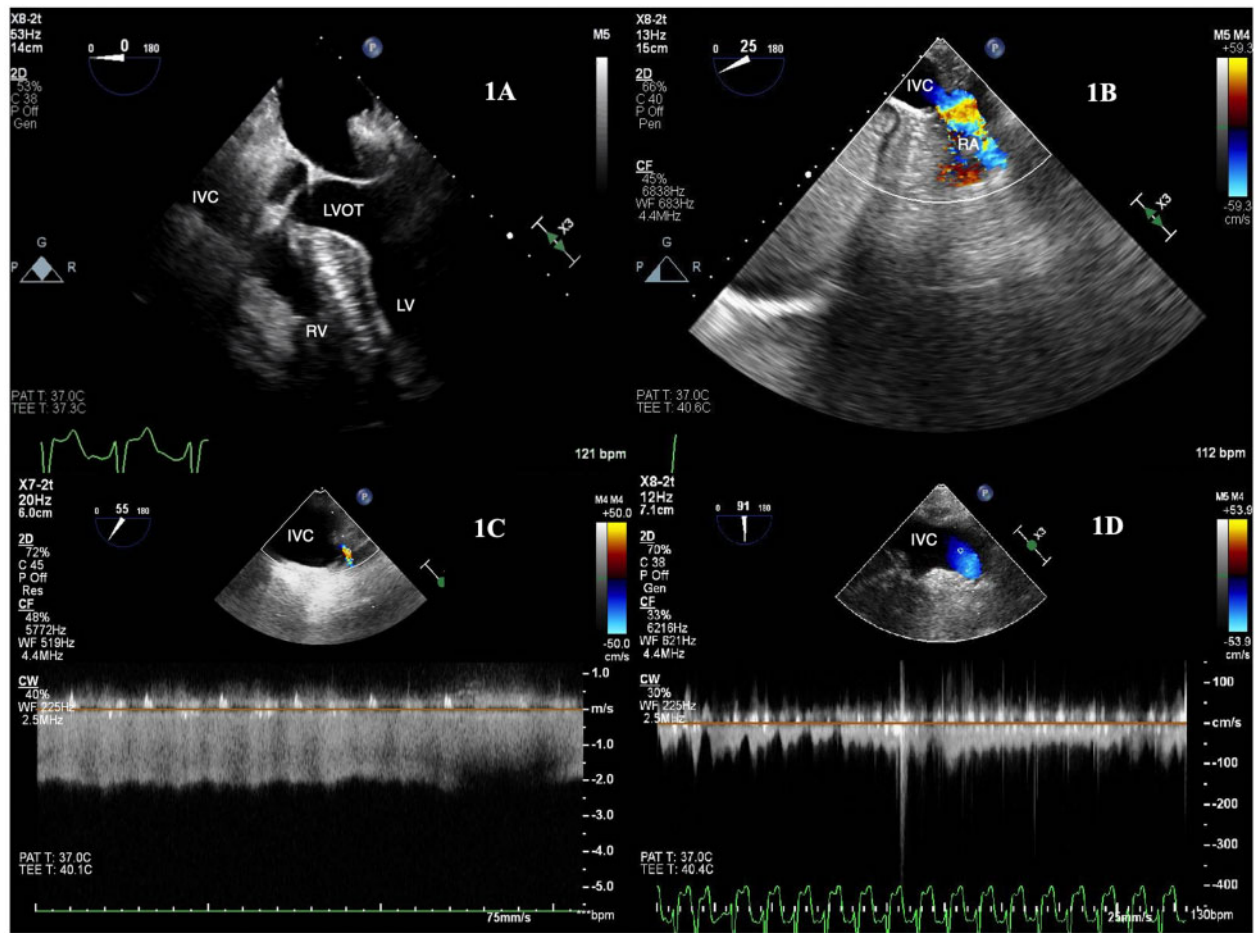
Case 1: Transoesophageal echocardiogram images following bicaval heart transplantation. (A) Underfilled right ventricle (B) Colour Doppler demonstrating flow acceleration across inferior vena cava-RA anastomosis (C) Continuous wave Doppler analysis demonstrating a significant pressure gradient across the inferior vena cava anastomosis (D) Continuous wave Doppler showing resolution of pressure gradient following resection of Eustachian valve.
